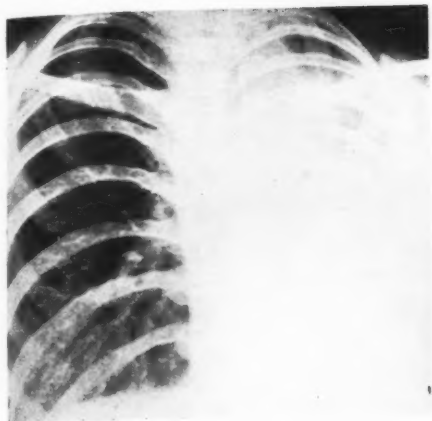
X-ray of chest showing an almost opaque left hemithorax consistent with collapse of the left lung.
